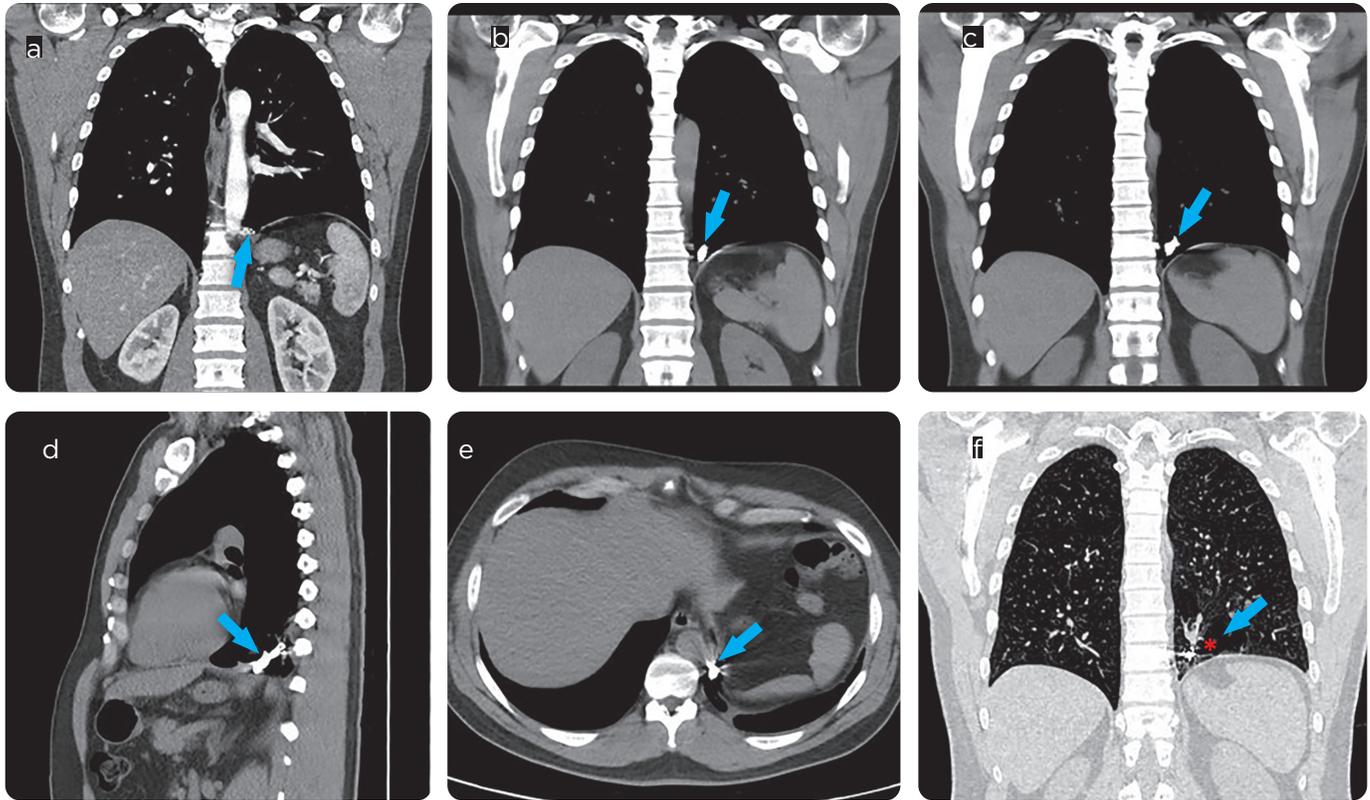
Sequence of CT images of the chest in a) coronal, b) and c) coronal cuts, d) sagittal and e) axial, in cuts similar to figure 2 (comparatively pre-treatment and post-treatment), showing surgical embolization material (blue arrow) in aberrant artery vessel and f) coronal cut in lung window, showing fibrous tracts and volume loss of the compromised segment (asterisk). Normal changes expected for the procedure.
